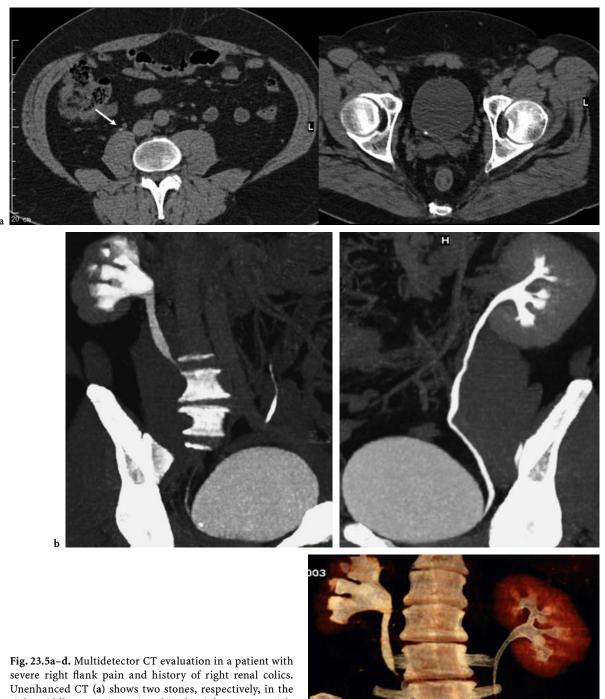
Multidetector CT evaluation in a patient with severe right flank pain and history of right renal colics. Unenhanced CT (a) shows two stones, respectively, in the right middle ureter (arrow) and in the right ureterovesicle junction. Coronal oblique MIP images in the excretory phase (b,c) demonstrate moderate right hydronephrosis and slight dilation of the proximal ipsilateral ureter with partial obstruction at the level of the middle ureteral stone; in addition, the presence of the right ureterovesicle junction stone is confirmed, with non-dilated distal ureter. The left normal ureter is seen along its entire course. VR CT urography (d) better depicts the entire collecting system of both kidneys, showing right pyelocaliectasis with reduction of renal cortical thickness
